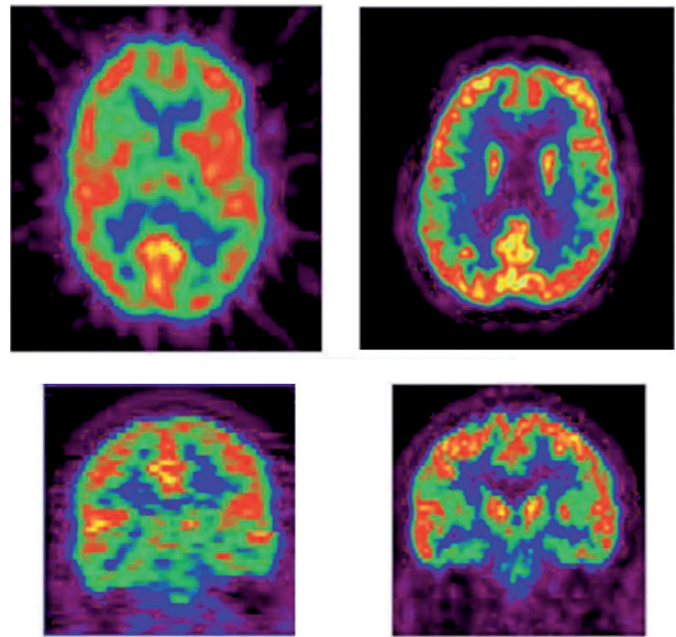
The appearance of partial volume effects in PET images. Grey matter is fourfold as metabolically active as white matter. The *top* panel shows two transverse sections of an FDG image obtained on an older instrument, Siemens ECAT 953B, and reconstructed to a final image resolution of approximately 10 mm FWHM (left) and an FDG image from another patient, taken at approximately the same levels, obtained on a more modern instrument, Siemens Biograph 16 PET/CT, and reconstructed to a final image resolution of 5 mm FWHM (right). The *bottom* panels shows coronal sections from the same patients using the Siemens ECAT 953B (left) and Siemens Biograph 16 PET/CT (right). The *left* panels shows blurring of the activity in grey matter, white matter, and ventricles. The *right* panels shows essentially only the grey matter ribbon, whereas the white matter and CSF are at the lower end of the color scale (blue/black). There is still some green at the interface between grey matter and white matter from some residual partial volume effects. (see Color Plate 12, following p. 650).
